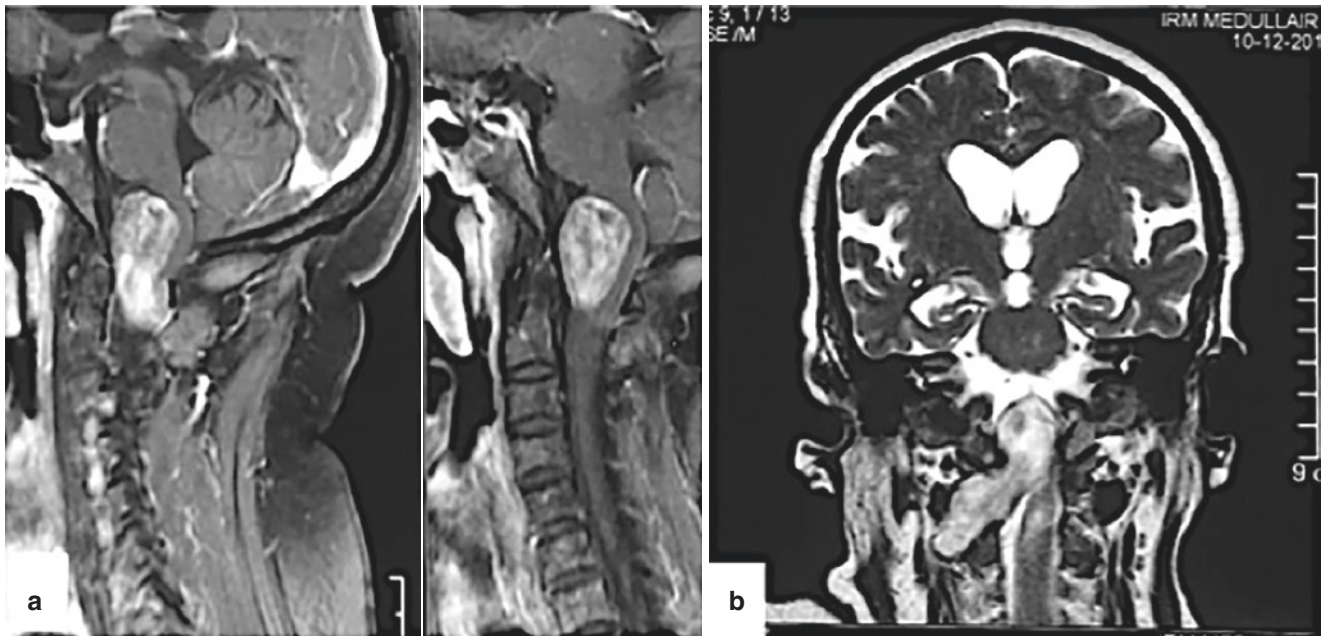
Preoperative MRI: sagittal T1 post gadolinium (a) and coronal T2 weighted images (b) showing a process of foramen magnum with an important compression of medulla oblongata
